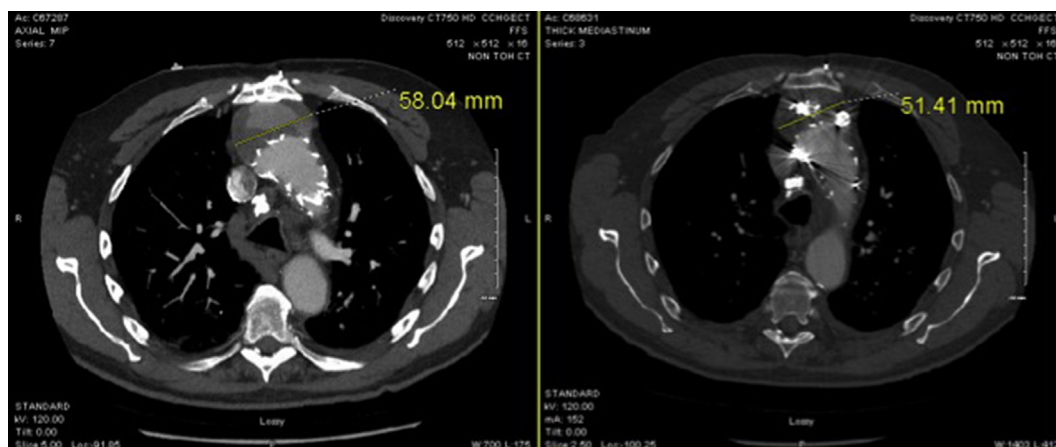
Contrast-enhanced CT scans performed pre- and post-embolization of the pseudoaneurysm sac, demonstrating reduction in aneurysm size to 5.1 cm and no endoleak.
